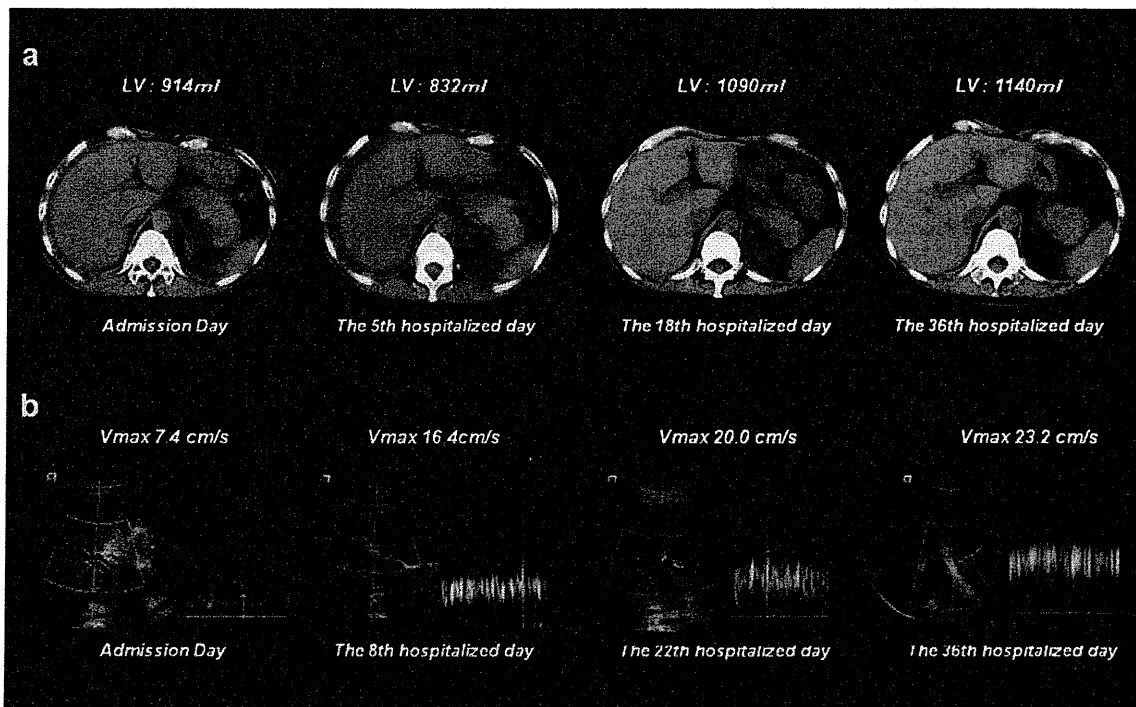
The changes in the liver volume and blood flow of the right portal vein during the clinical course. (A) The change in liver volume. The liver volume measured by CT was 914 ml on admission day. Although the progression of liver atrophy was seen on the 5th day of disease, with a volume of 832 ml, evidence of recovery was seen on the 18th and 36th days of disease, with volumes of 1090 and 1140 ml, respectively. (B) Although the blood flow in the right portal vein was decreased to 7.4 cm/s on the day of admission, it later increased to 16.4, 20, and 25.7 cm/s on the 8th, 22nd, and 36th days of disease, respectively.
